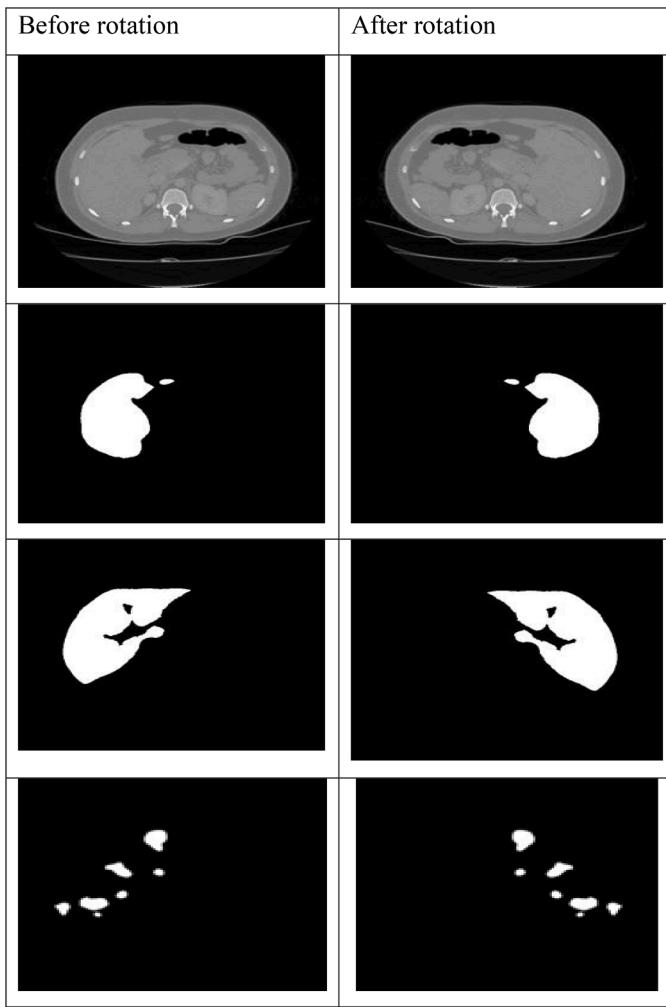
3Dircadb CT slices before and after rotation
